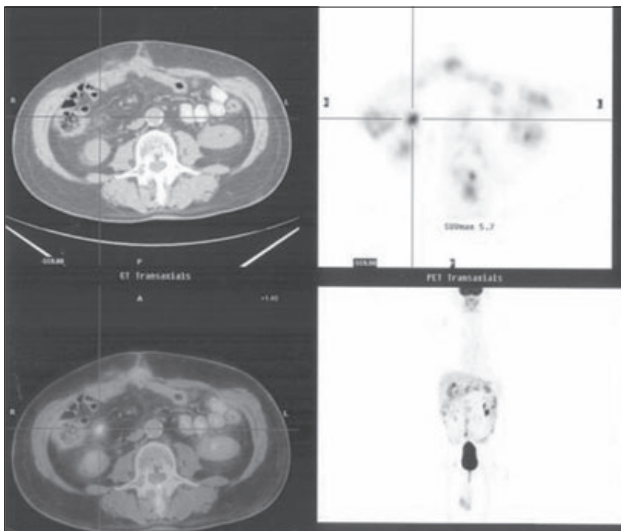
PET-CT fusion. Suspected locoregional recurrence of carcinoma of colon sigmoideum in the right mesogastrium.
